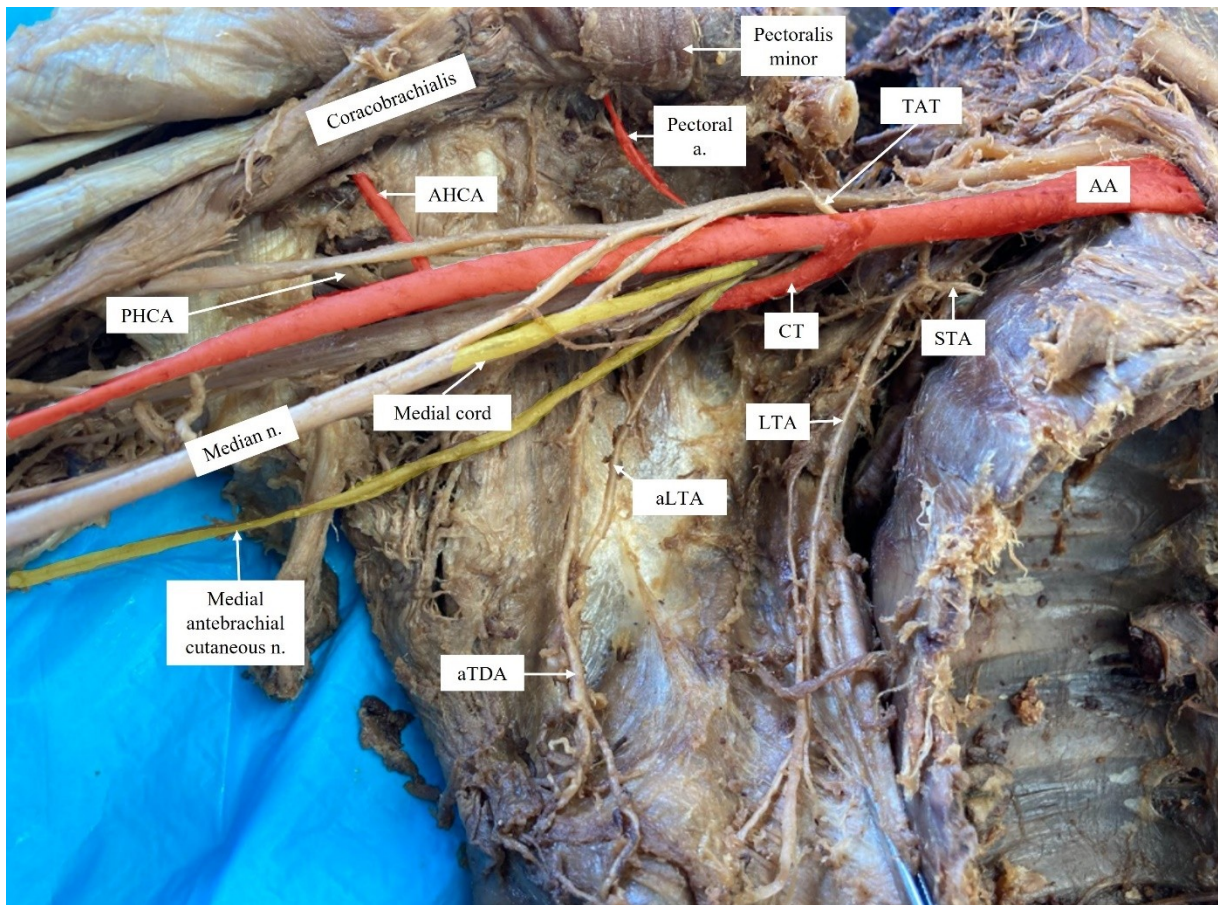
Unique neurovascular relationship between brachial plexus and AA. The pectoral artery and AHCA can be observed branching from the second and third parts of the AA, respectively. Arterial structures have been shaded in red to emphasize the unique anatomical relationship of the AA and the CT with two neural structures, the medial cord and the medial antebrachial cutaneous nerve, that are shaded yellow. The two branches from the second and third parts of the AA are also in red. This image also allows one to appreciate the LTA supplying the STA.
